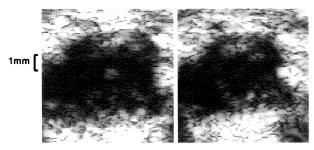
Two-dimensional echocardiograms without contrast agent (left: end-diastole; right: end-systole).
